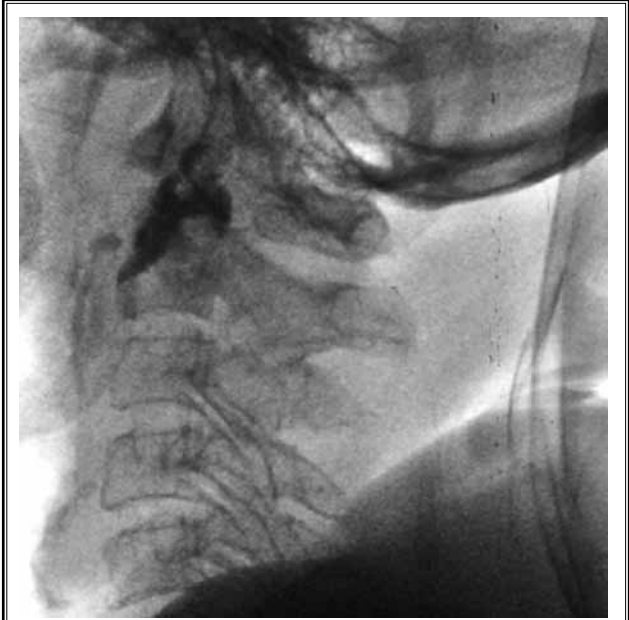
Lateral radiograph obtained after vertebroplasty shows cement deposition in C2.
